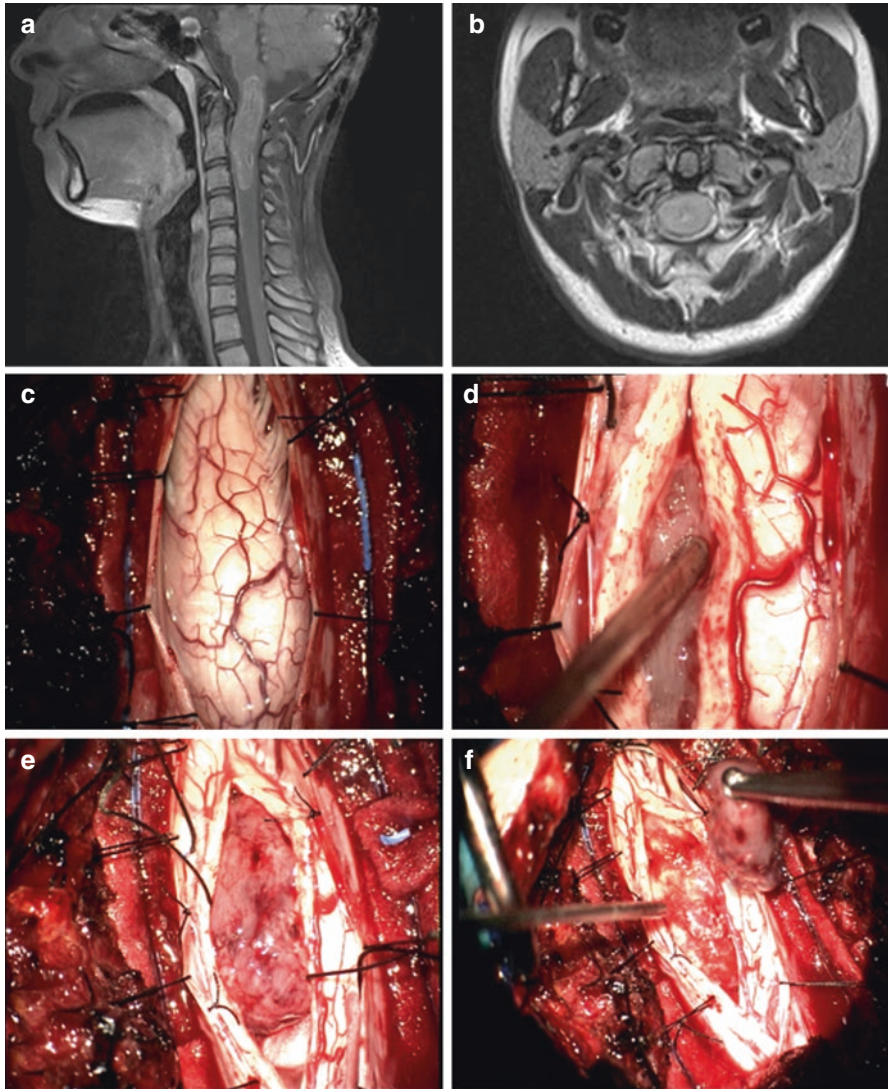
(a) Preoperative T2-weighted MRI of a cervical-intraductal ependymoma on sagittal T1 section. (b) T1-axial non-contrast T2-weighted MRI revealing an intramedullary lesion. (c) Intraoperative view of the enlarged spinal cord following midline dural incision. (d) Intraoperative view of an intramedullary ependymoma following myelotomy. (e) Following tenting of the dura and the pial membrane, general view of the tumor with its superior and inferior poles. (f) Total removal of the tumor and the resulting tumor cavity
